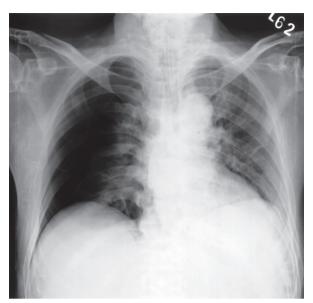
The postintubation chest radiograph shows marked collapse of the middle and lower lobes of the right lung with a deep sulcus sign lateral to the right hemidiaphragm. No visible foreign body in the airway could be identified in this radiograph.
